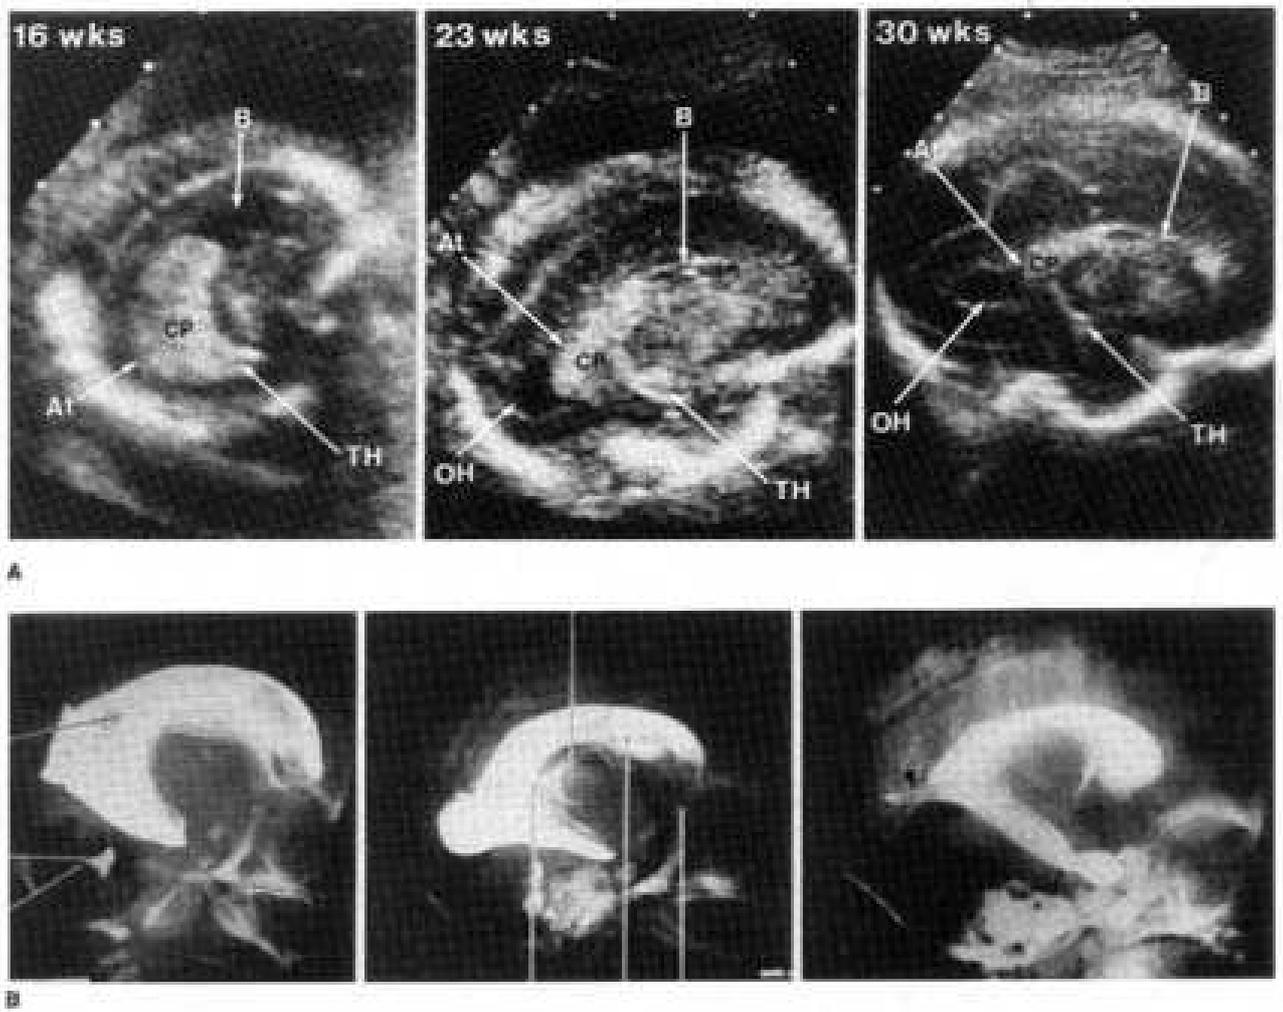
(A) Developmental changes of the lateral ventricles during gestation on sagittal US images shows that at 16 weeks, the ventricle occupies most of the hemisphere. The occipital horn has not yet developed, and the atrium (At) is posteriorly blunt. The prominent choroid plexus (CP) fills most of the ventricular cavity. Note the high roof of the body (B) of the lateral ventricle. At 23 weeks, the ventricle is reduced considerably in size, and the occipital horn (OH) starts to develop. At 30 weeks, the occipital horn is fully developed. TH, temporal horns. (B) Sagittal Barium casts of the fetal lateral ventricles at 16, 23, and 30 weeks of gestation. Note the similarity to the ultrasound images (Pilu et al, 2002).
